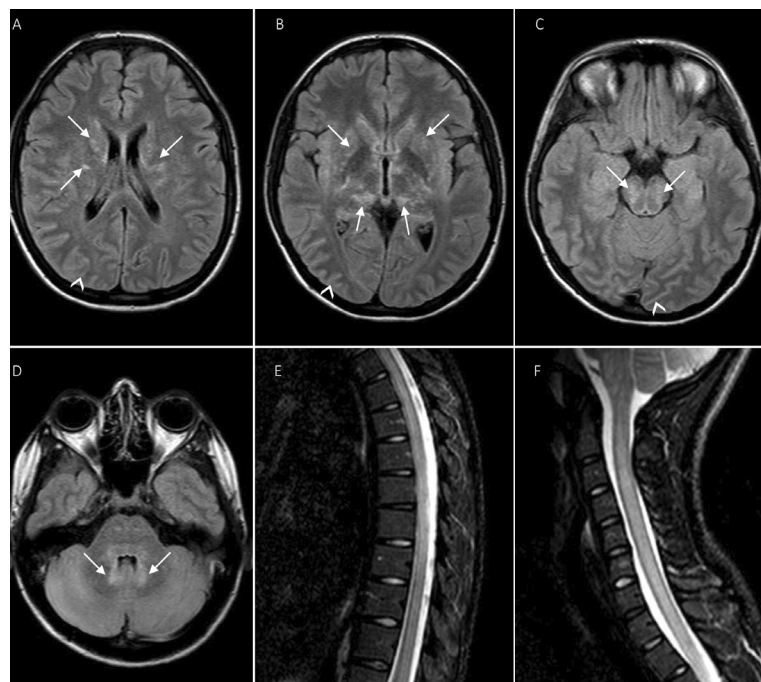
Brain MRI showing bilateral axial FLAIR hyperintensities (arrows) in the periventricular white matter (A), basal ganglia and thalami (B), brainstem (C) and dentate nuclei of cerebellum (D) and hyperintense sulci on the posterior temporal and occipital lobes (arrowheads A–C). Spinal MRI sagittal STIR showed a longitudinally extensive transverse myelitis (E–F), extending from the cervical spinal cord to the conus medullaris. FLAIR: fluid attenuated inversion recovery; STIR: short tau/TI inversion recovery.
